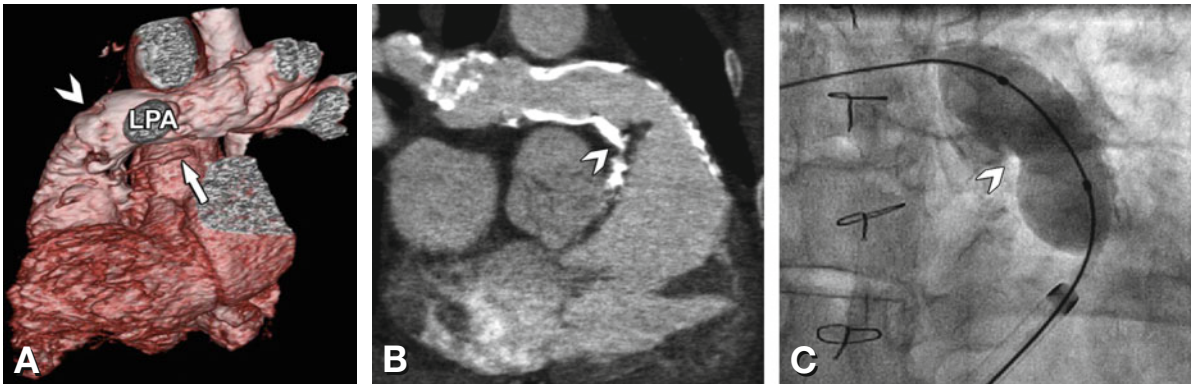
CT evaluation prior to percutaneous pulmonic valve implantation. The spatial relationship between the coronary arteries and the conduit and the distance of the conduit from the main pulmonary artery branches should be evaluated. Panel A shows the three-dimensional volume rendering indicating the location of the left anterior descending coronary artery (*arrow*) and the right ventricular outflow tract (RVOT) conduit (*arrowhead*) and left pulmonary artery (LPA). The coronary artery is far from the conduit. Panel B shows the distance between the main pulmonary artery branches and the site of conduit stenosis (*arrowhead*). Panel C shows the fluoroscopic view of the balloon with the arrowhead indicating the area of ingrowth and stenosis within the conduit. Ao aorta; RA right atrium; RPA right pulmonary artery; RV right ventricle
